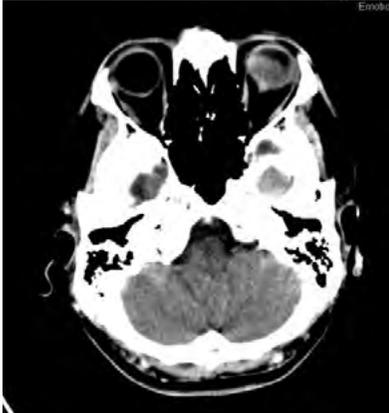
Cranial CT (axial cut) of the patient showed a layering hyper-density in the posterior chamber of the left globe.
